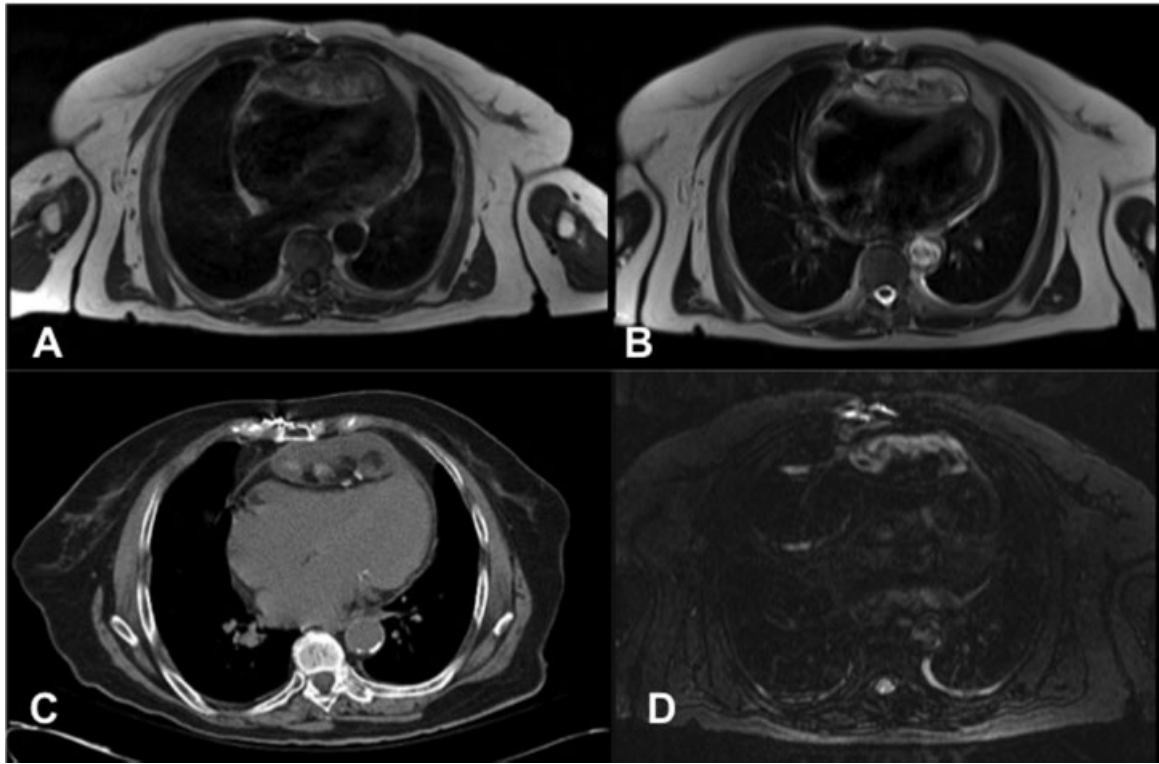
(A) MRI T1 sequence, (B) MRI T2 sequence, (C) CT scan image, and (D) MRI STIR sequence. CT, computed tomography; MRI, magnetic resonance imaging; STIR, short time inversion recovery.
